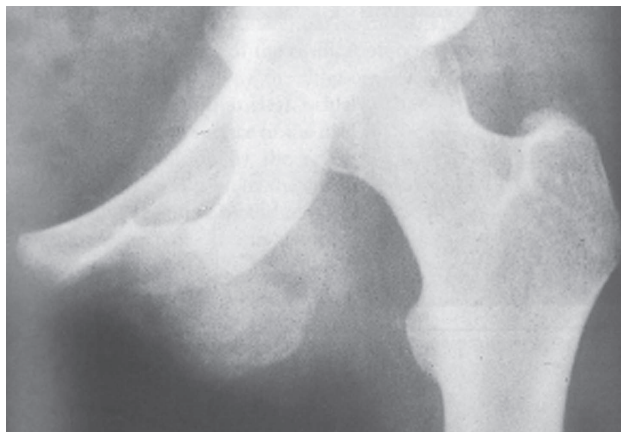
X-ray demonstrating early bone formation of heterotopic ossification. From *Orthopaedic Pathology* (2nd ed.), by V. J. Vigorita, 2008, Philadelphia, PA: Lippincott Williams & Wilkins.
